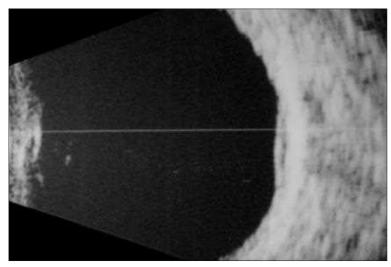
B-Scan Ultrasound Image of Slightly Elevated Choroidal Nevus. The Tumor Appears Fusiform in Cross-Sectional Shape and Exhibits Moderately High Internal Sonoreflectivity.
